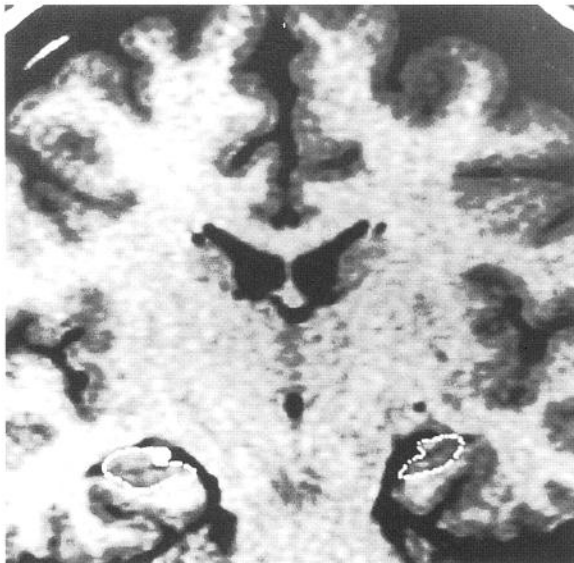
Coronal magnetic resonance imaging scan (Patient 18) passing through the hippocampal bodies showing severe left hippocampal atrophy (ratio = 0.59).
